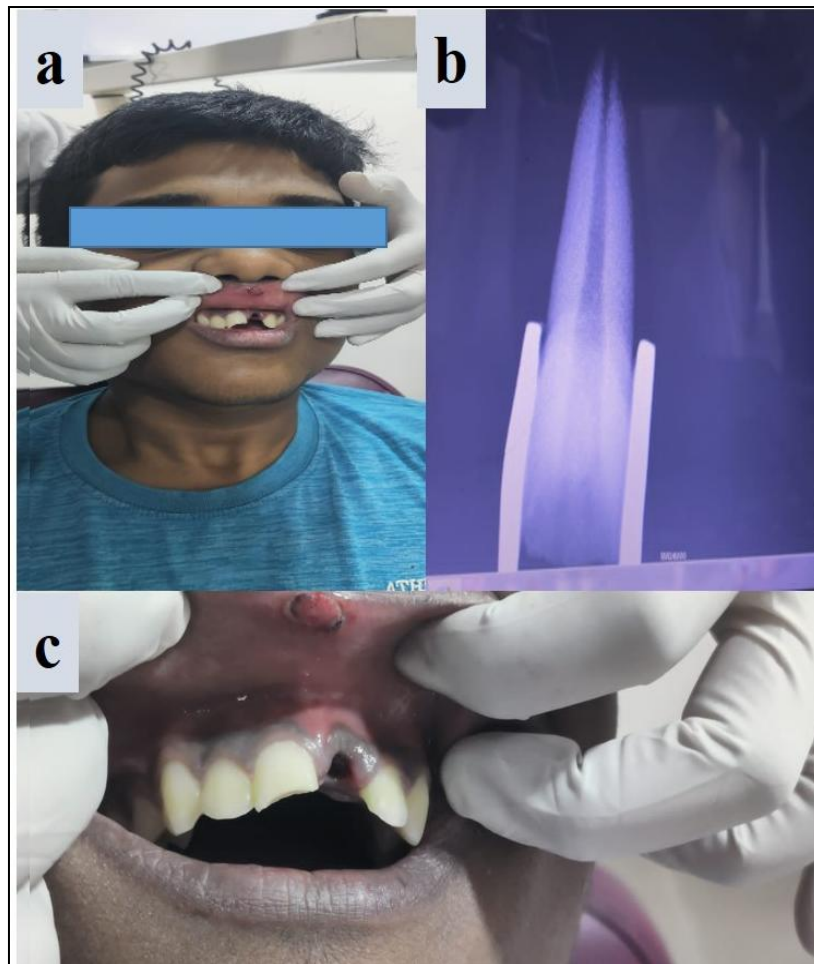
a) Patient came with a traumatic injury, b) Pre-op radiographic image of avulsed teeth, c) Intra oral view shows lip abrasion and missing tooth
